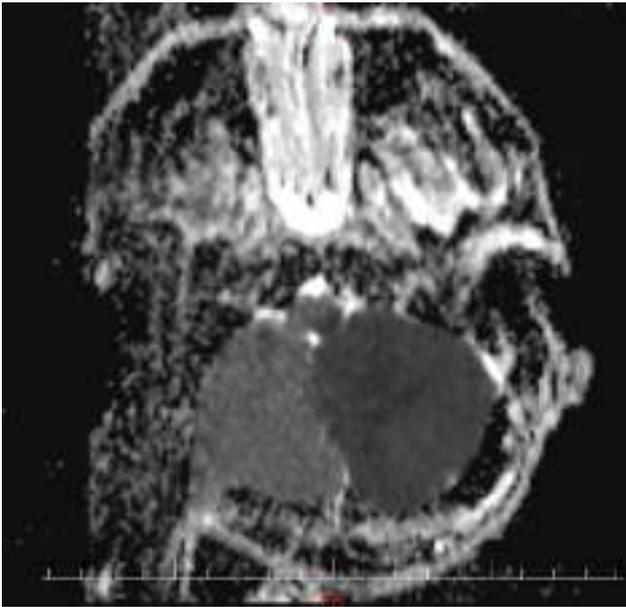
MRI showed an acute cerebellar infarct in the left posterior inferior cerebellar artery territory
